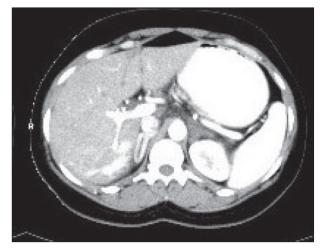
Contrast computed tomography scan showed enlarged hypodense left adrenal gland with normally enhancing right adrenal gland
